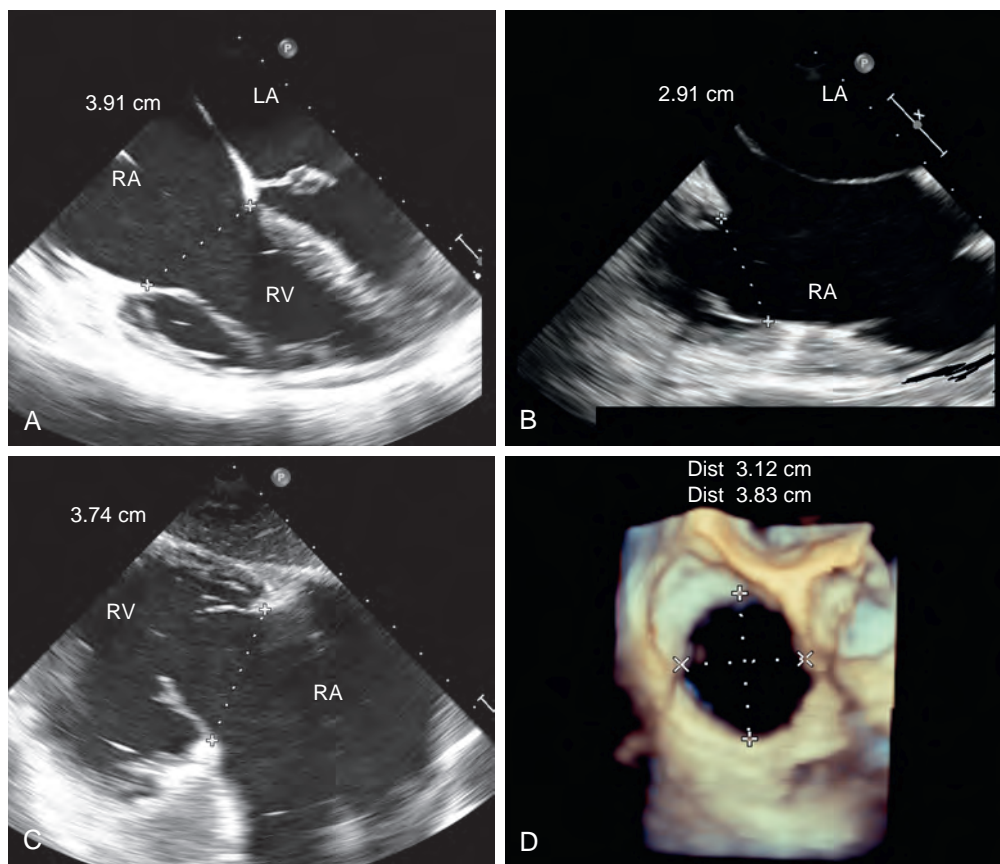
Annular diameter assessment with two- (2D) and three-dimensional (3D) imaging. The introduction of 3D imaging demonstrates that the shape of the tricuspid valve (TV) annulus is not easily predicted. (A–C) Significant variability of the 2D annular diameters likely represents variations of the imaging plane and rotation of the transesophageal echocardiography probe. (D) The 3D image is able to identify these variabilities and perhaps yield a more accurate assessment of TV annular dimensions. However, to this date, tricuspid regurgitation outcomes are still based on 2D imaging. LA, Left atrium; RA, right atrium; RV, right ventricle.
